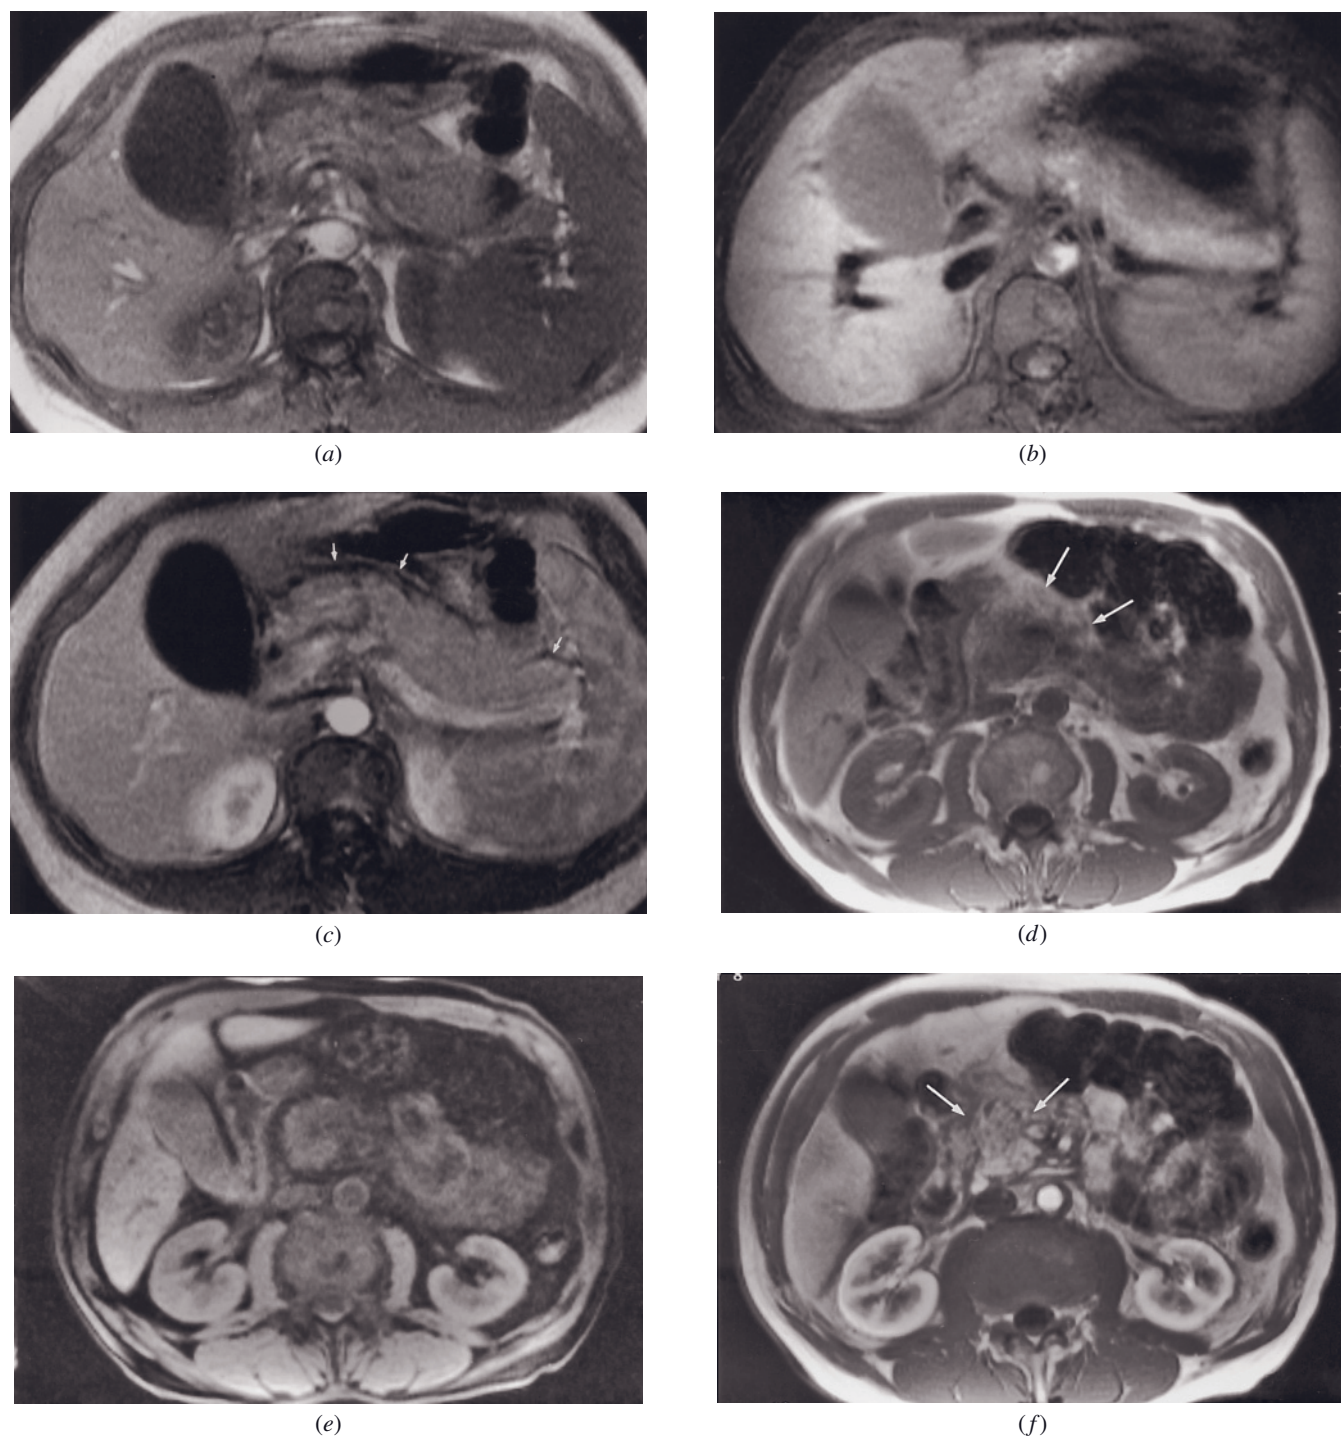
Moderately severe acute pancreatitis. T1-weighted SGE (*a*), T1-weighted fat-suppressed spin-echo (*b*), and immediate postgadolinium T1-weighted SGE (*c*) images. The pancreas is diffusely enlarged (*a*–*c*). The signal intensity of the pancreas is heterogeneous on the T1-weighted fat-suppressed image (*b*), which suggests a decrease in the proteinaceous fluid content within the acini of the pancreas. Signal-void fluid is shown surrounding the body and tail of the pancreas on the immediate postgadolinium image (arrows, *c*). The intensity of pancreatic enhancement is less than normal for pancreas on the capillary-phase image (*c*).
